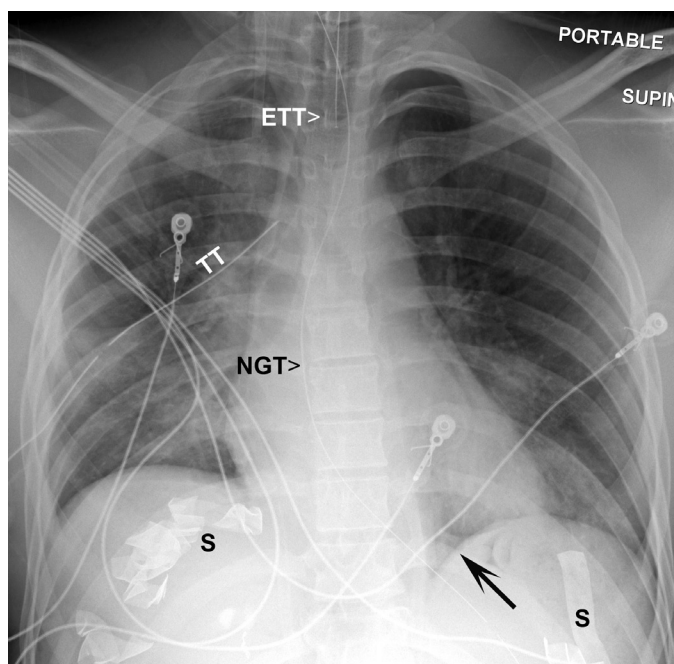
■ Anteroposterior (AP) supine chest x-ray. Left medial “deep sulcus sign” (*black arrow*) is consistent with a pneumothorax on a supine chest x-ray. ETT, endotracheal tube, NGT, nasogastric tube, and TT, thoracostomy tube, are in proper good position. Postsurgical sponges/packing (S) are present in both upper abdominal quadrants.
